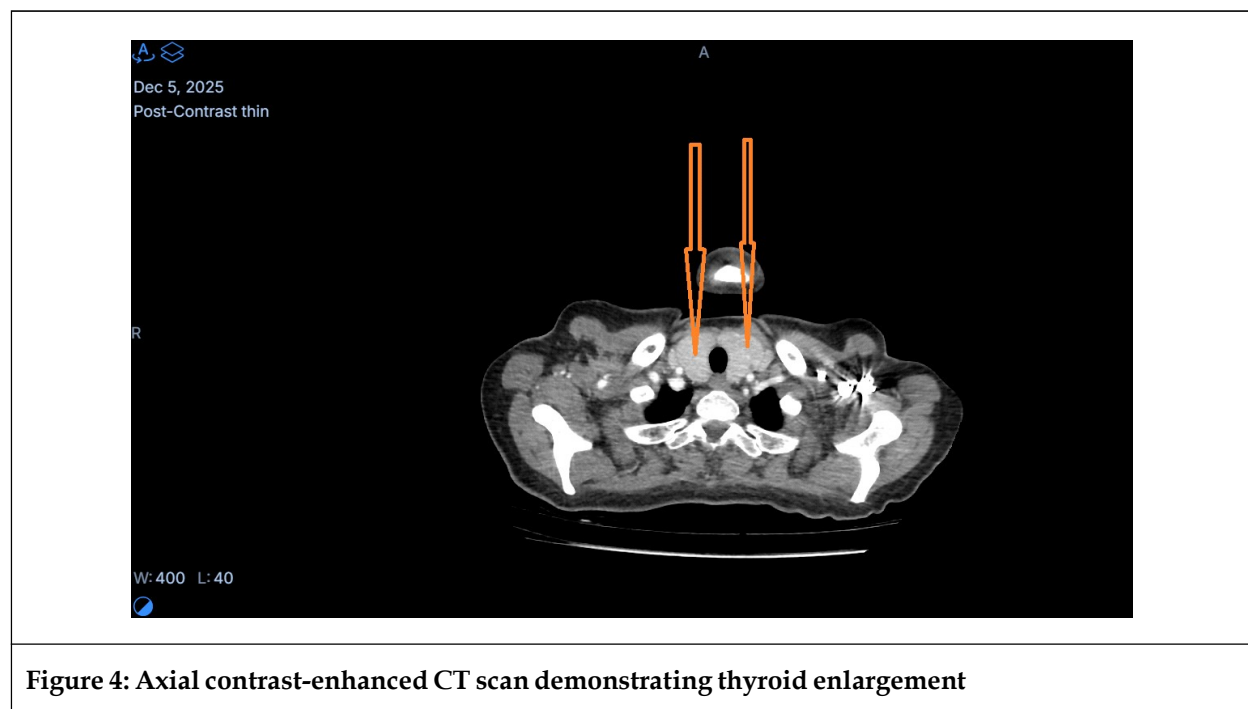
Axial non-contrast CT scan demonstrating thyroid enlargement
